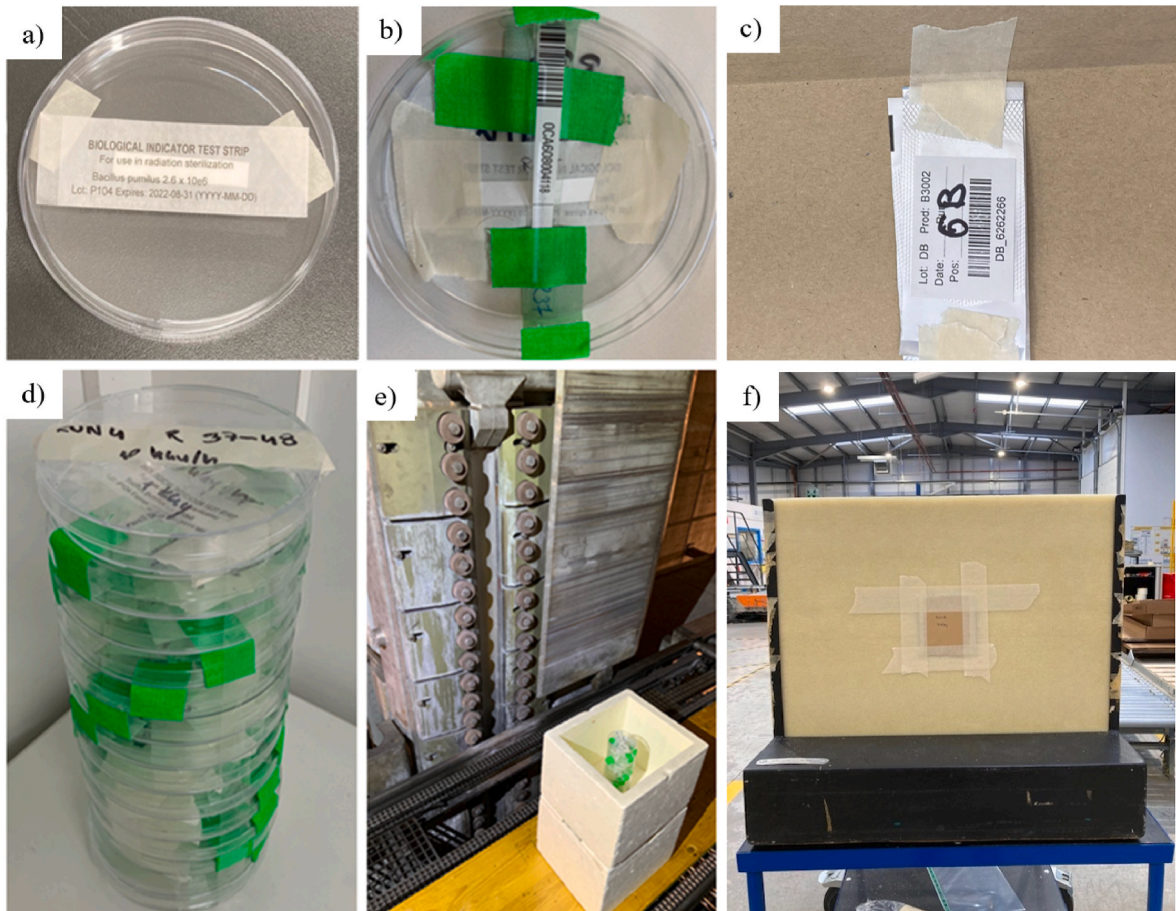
Experimental set-up. Sample preparation (configuration) was identical for X-ray and gamma: biological indicators were placed in a Petri dish (a) together with dosimeters (b), and stacked Petri dishes were irradiated (d). Placement at X-ray in static mode in front of the beam is shown in panel e. For e-beam irradiation, one biological indicator was placed in between two dosimeters and taped in the middle of a paper envelope (c), while two individual biological indicators used for microbiological analysis were then taped, one on the left and the other on the right side of the dosimeter (not shown in the figure). Sample placement on the carrier (paper envelope fixed to the middle of the carrier) for e-beam treatment is shown in panel f.
